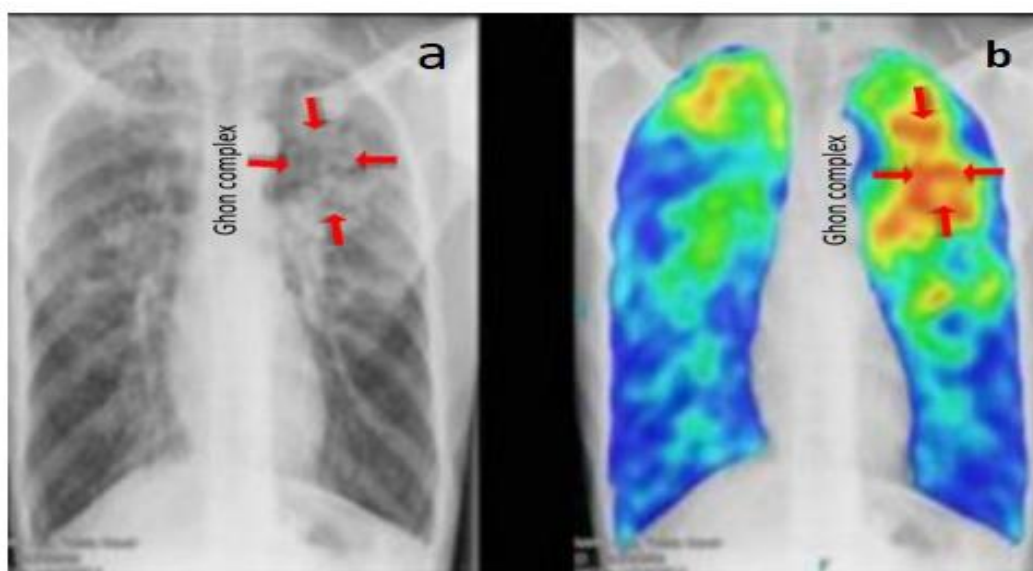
[a] Chest X-ray, [b] Dual -energy Chest radiography
